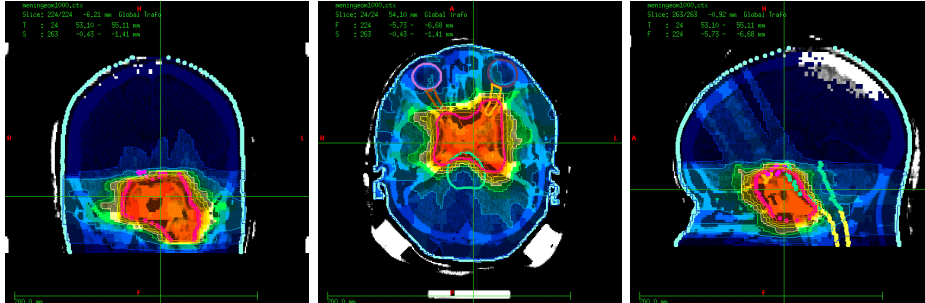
CT images of the brain cancer case overlaid with the 0 T dose distribution: frontal, transverse and sagittal plane (from left to right).
